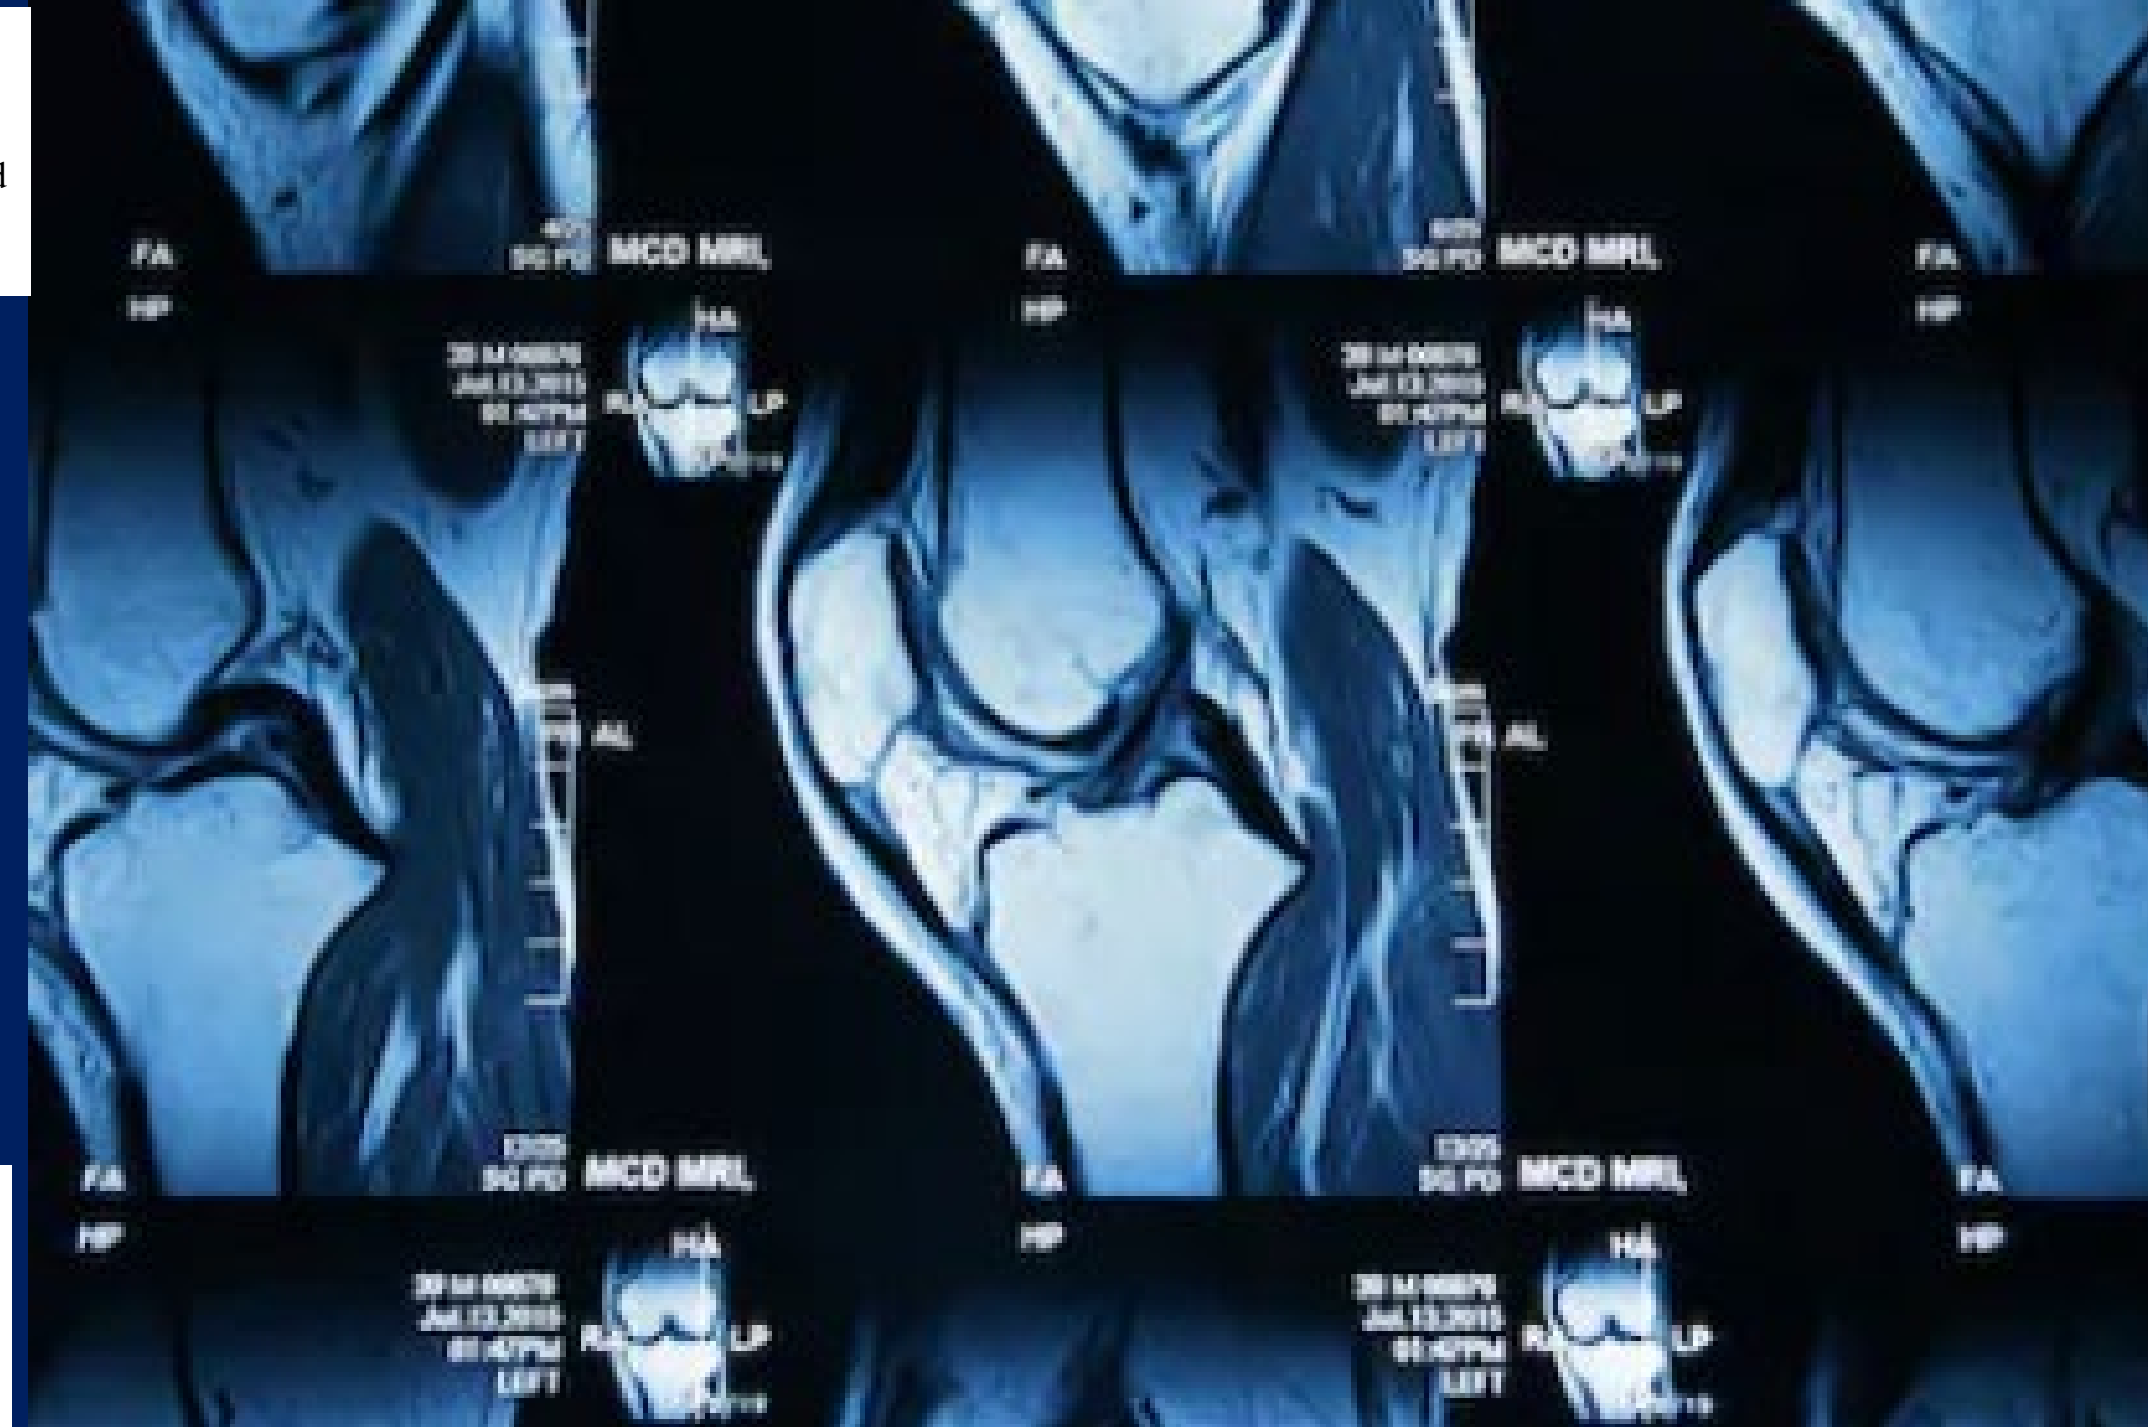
MRI of lower extremity injury.
